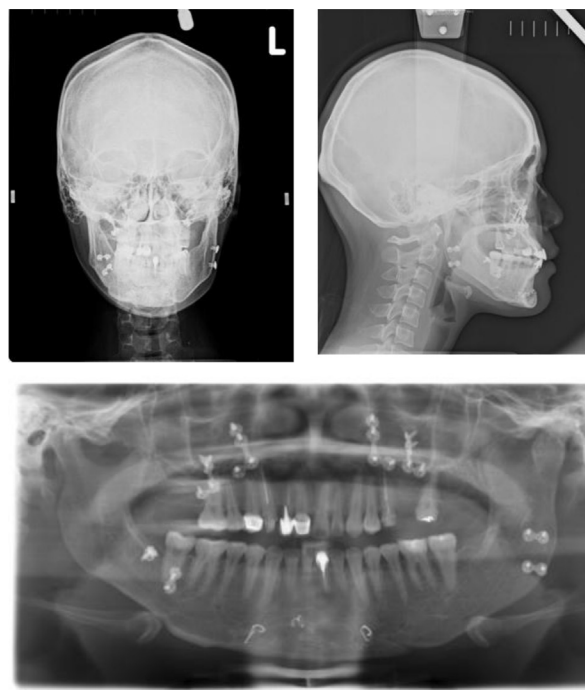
Posttreatment PA and lateral cephalometric and panoramic radiographs. The reconstructed left mandibular condyle was well remodeled.
